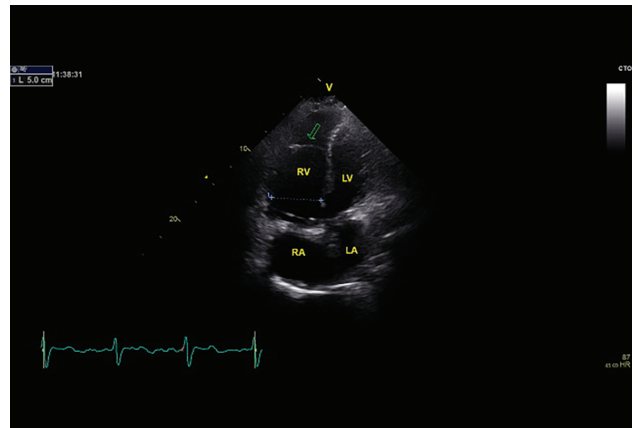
Apical four chamber view – bioprosthetic tricuspid valve placed in position of anatomic tricuspid annulus, lesser degree of right ventricle dilatation; arrow shows native tricuspid valve.
